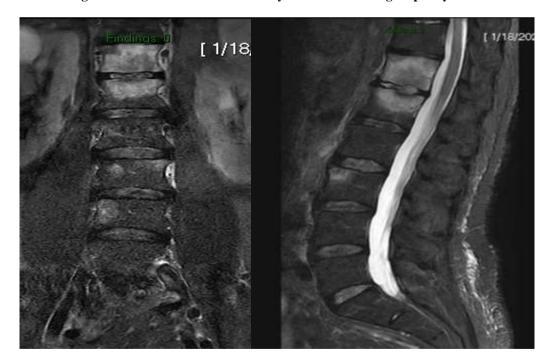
Lumbosacral spine T2, STIR and contrast enhanced T1-weighted magnetic resonance imaging shows abnormal signal change with enhancement in T12 and L1 vertebral body and intervening disc. Abnormal signal change and enhancement is also seen involving the L3 vertebra.
